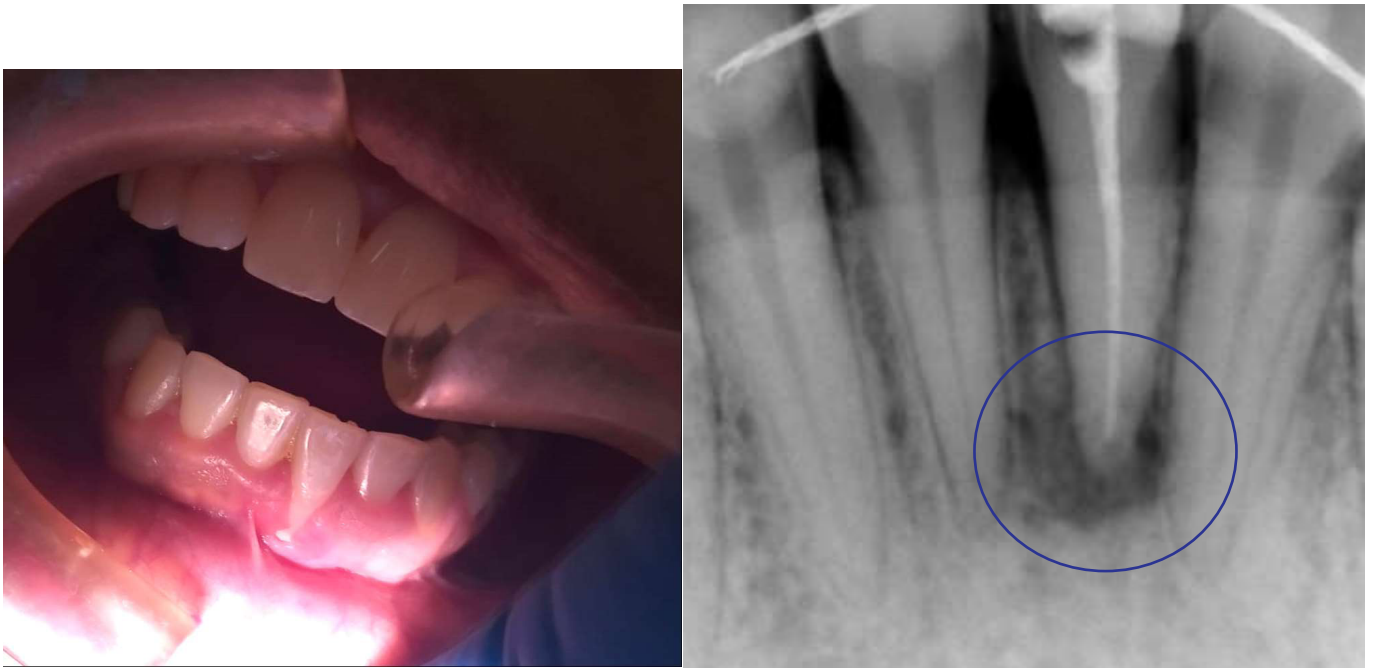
Final clinical and radiographic images showing completed root canal obturation and bone regeneration.*
